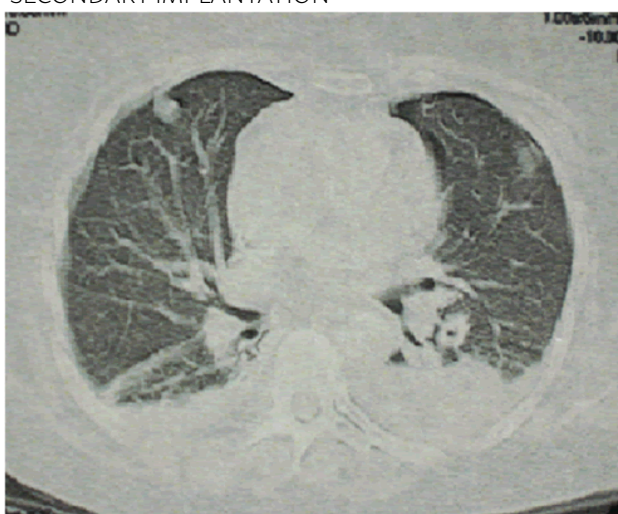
CONTRAST COMPUTED TOMOGRAPHY OF THE CHEST SHOWING BILATERAL PLEURAL EFFUSION, MORE PRONOUNCED ON THE LEFT, AND NODULES WITH WELL-DELINEATED MARGINS, SUGGESTIVE OF SECONDARY IMPLANTATION
